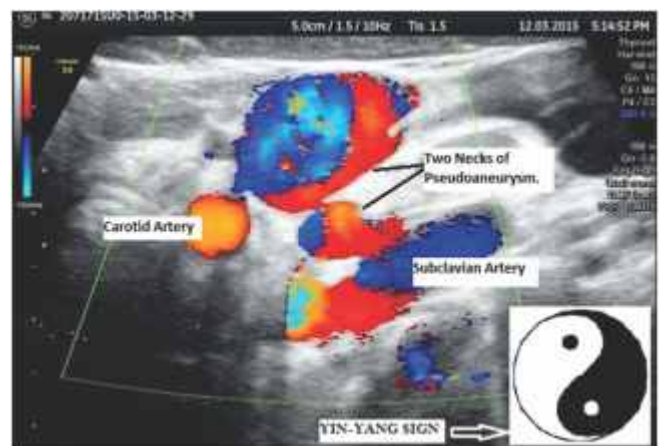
Color Doppler Ultrasound image of the Pseudoaneurysm demonstrates characteristic YIN-YANG SIGN (red-blue flow in the sac.)
